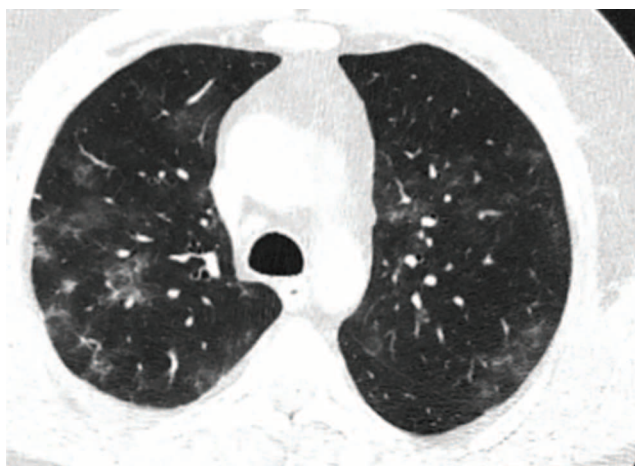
Chest CT. Ground-glass opacities and interseptal thickening.
